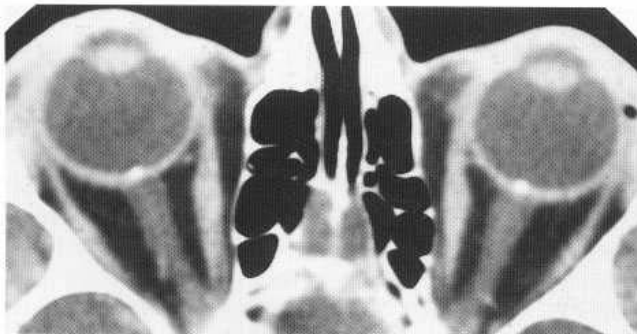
Drusen. CT shows bilateral punctate calcifications, located centrally over the optic nerve head.
